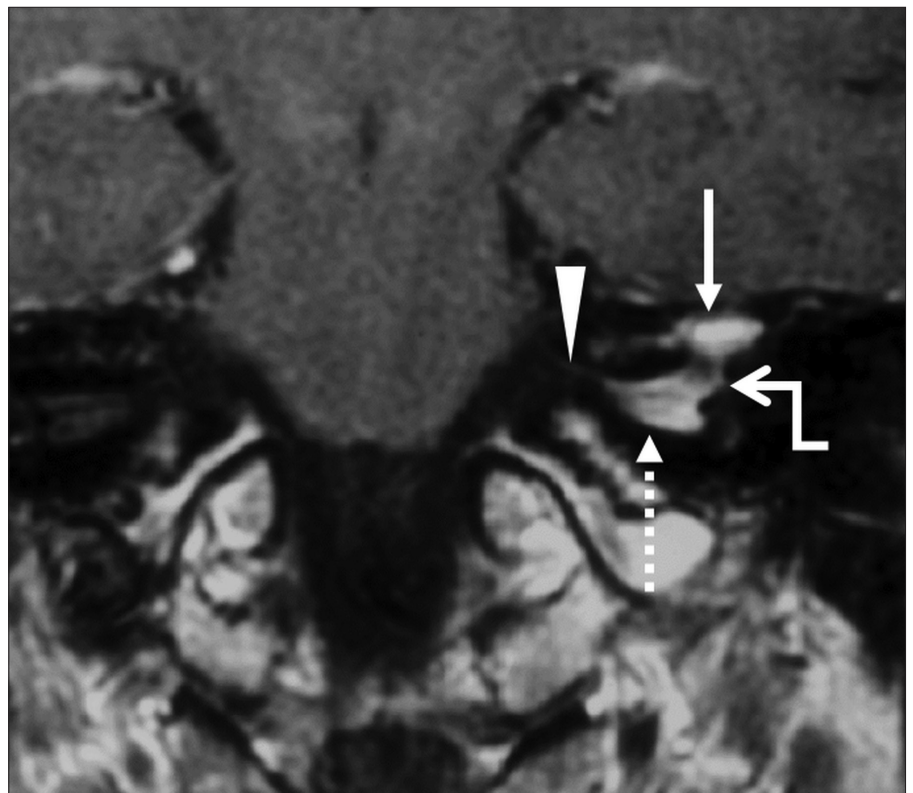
Contrast-enhanced coronal T1-weighted image through pons, at the level of the left IAC shows a dumbbell-shaped FNS. The isthmus of dumbbell is formed by the narrow labyrinthine segment of the FN (bent arrow), which connects the globular components in the IAC (dotted arrow) and those at the GG (arrow). The CPC segment of the FN (arrowhead) is not involved.
